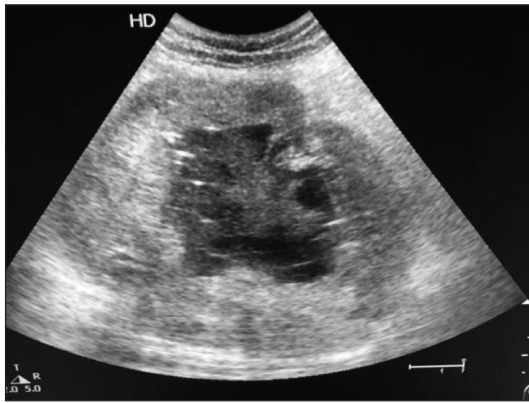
Ultrasound picture showing hematometra; loculations and blood entrapment in the uterine cavity.
